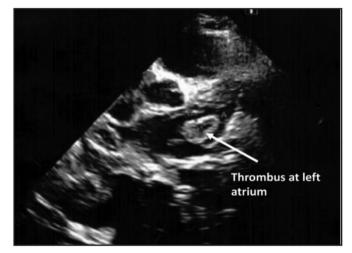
Echocardiography on day 6 admission showed a large left atrial thrombus at the left atrial appendage and extending to the body of the left atrium, measuring 8mm x 11.4mm.
